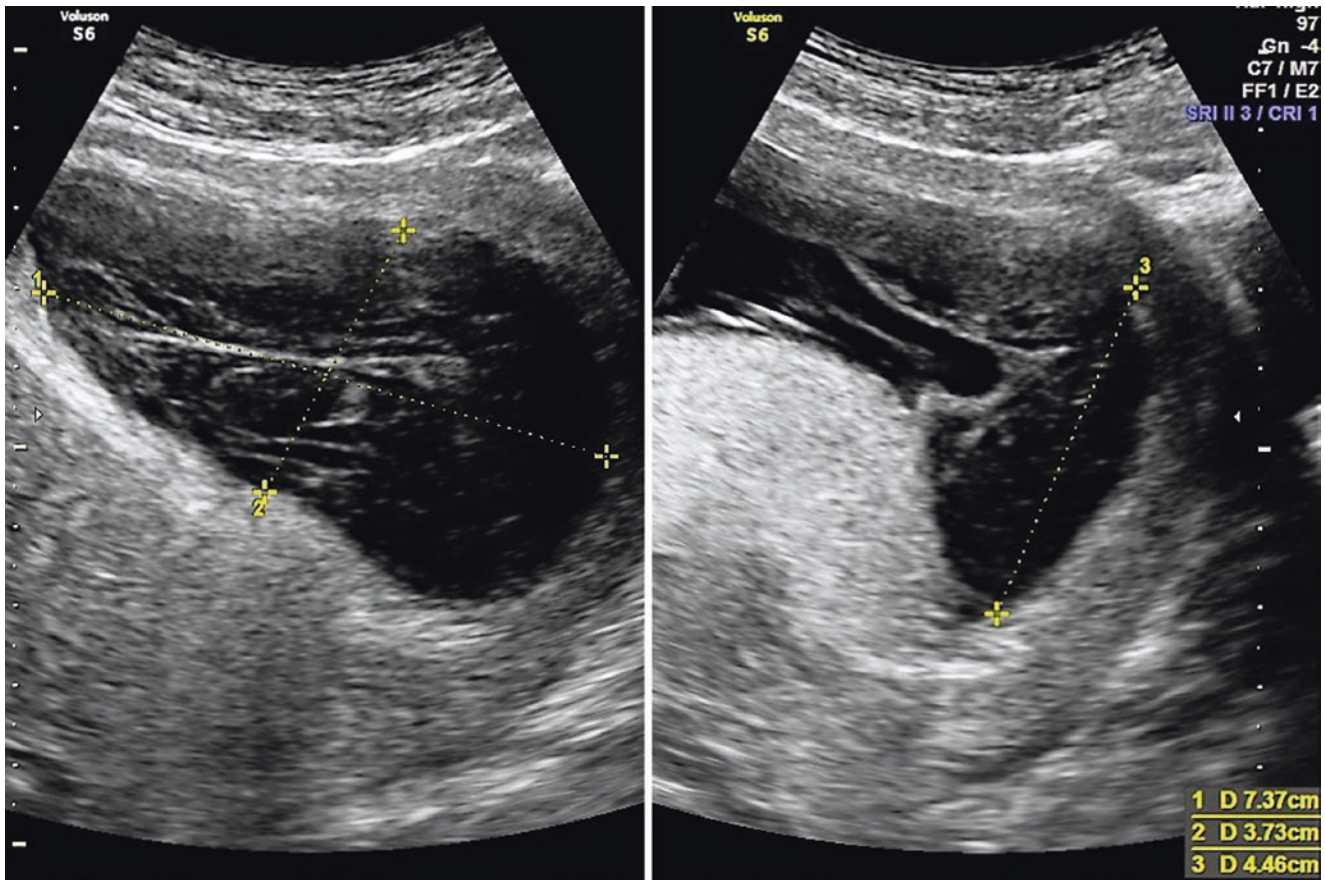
Transabdominal sonogram. Measurement of the volume of hematoma and the size of the detachment in the third trimester of pregnancy
